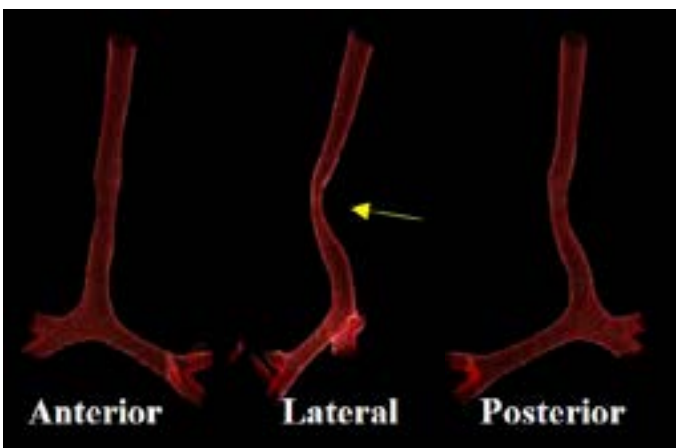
shows a CT reconstruction of the trachea of patient 3 before tracheoplasty. The lateral view (middle panel) shows the external compression on the trachea from a pulmonary artery sling (yellow arrow).
